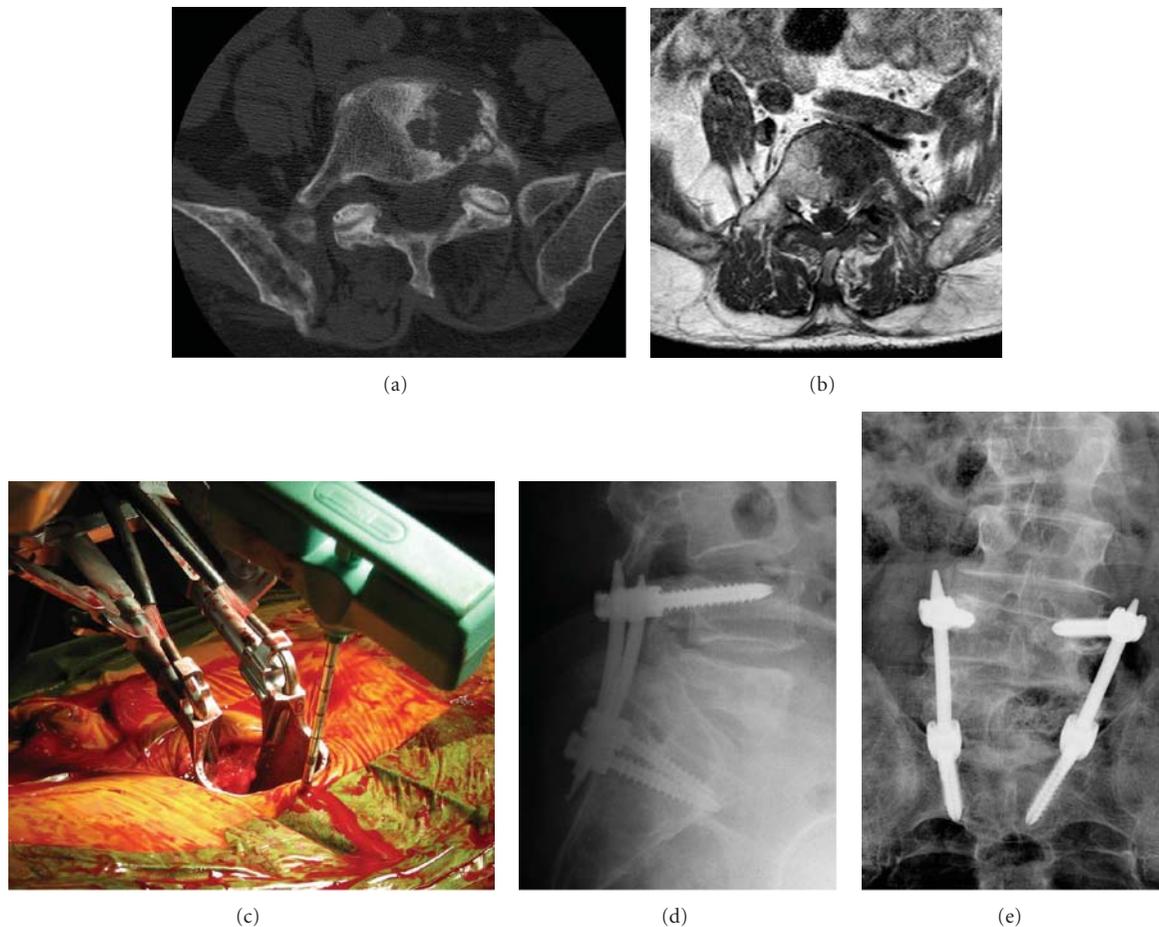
(a) This is a preoperative axial CT image of the L5 vertebrae demonstrating a lytic lesion from metastatic prostate cancer, (b) this preoperative axial MRI image demonstrates compression of the L5 nerve root on the left side, (c) this intraoperative photo demonstrates a trochar utilized to localize the pedicle prior to pedicle screw insertion, and it also demonstrates the minimally invasive access utilized for decompression of the L5 nerve root, (d) and (e) these are the postoperative a/p and lateral images demonstrating the L4-S1 instrumentation.
